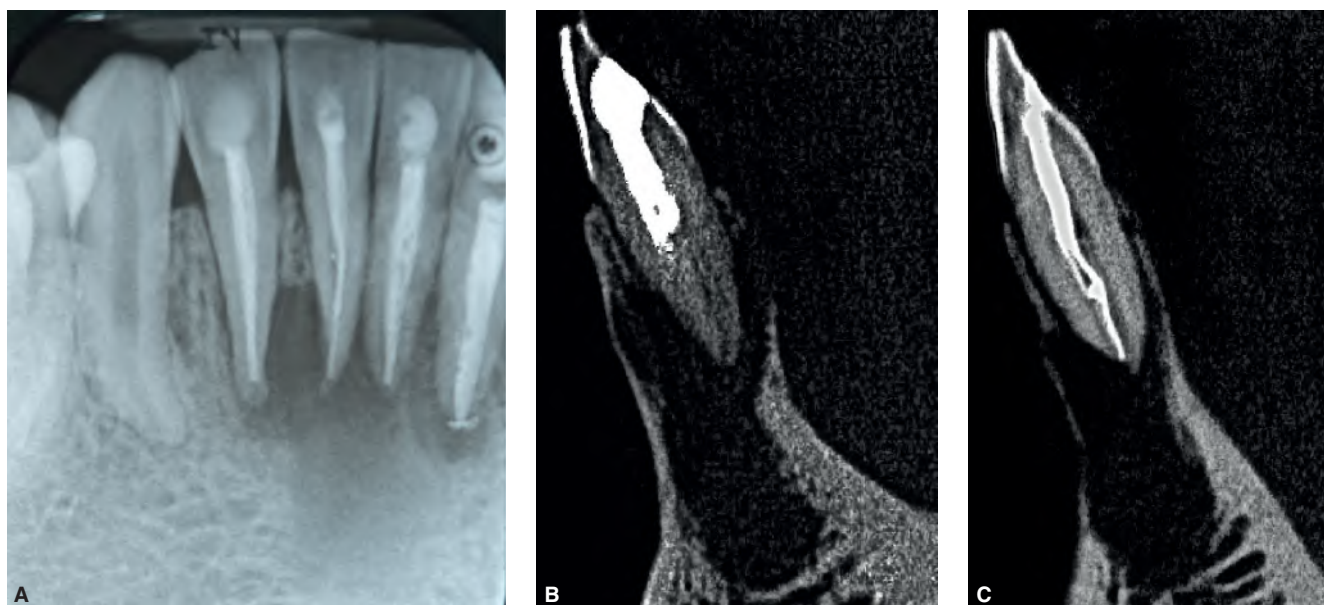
A. Periapical radiograph of the mandibular anterior region. B & C. CBCT reveals thin labial and lingual cortical bony plates that were not visible with conventional radiography. It also provides an accurate image of the extent of the periapical pathosis. This information is critical prior to endodontic surgery.
